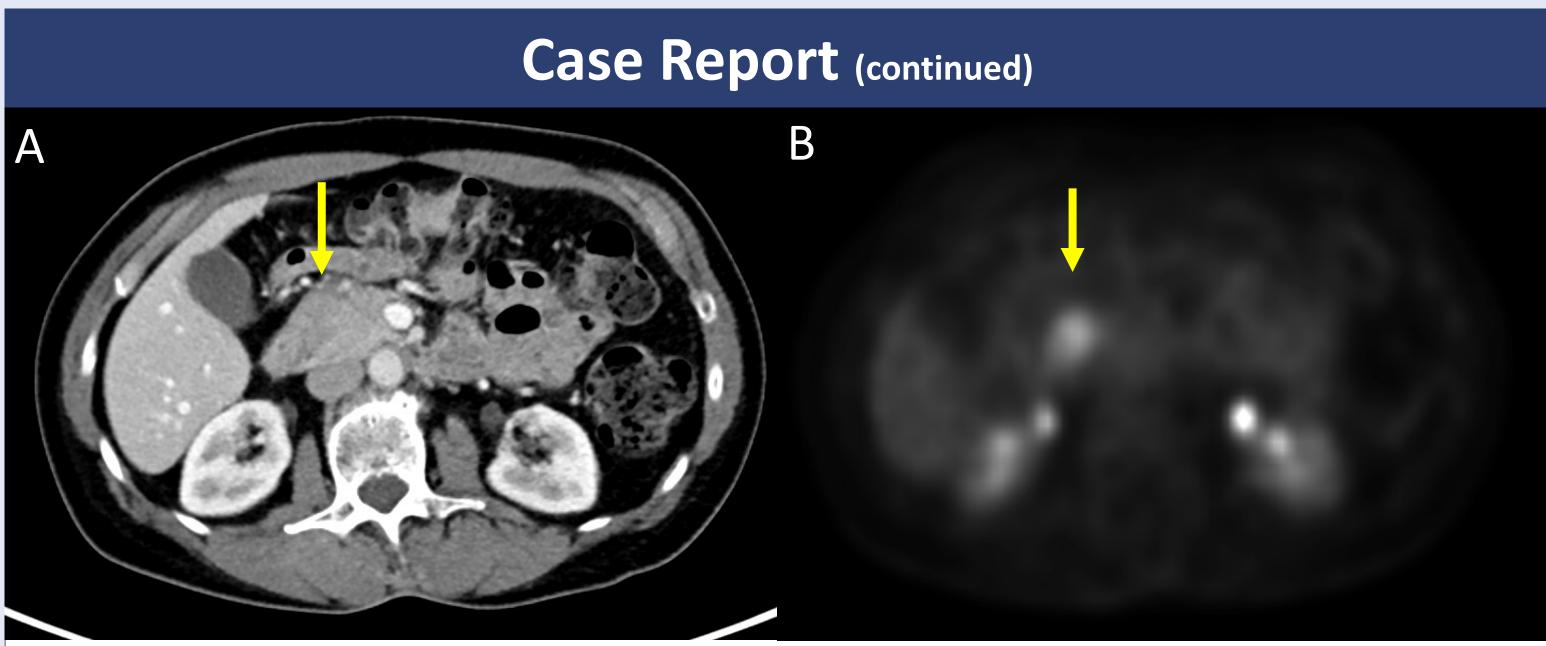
Contrast enhanced axial CT image shows hypo enhancing pancreatic head mass (yellow arrow) (A) which shows intense FDG avidity on the corresponding PET image (B).
